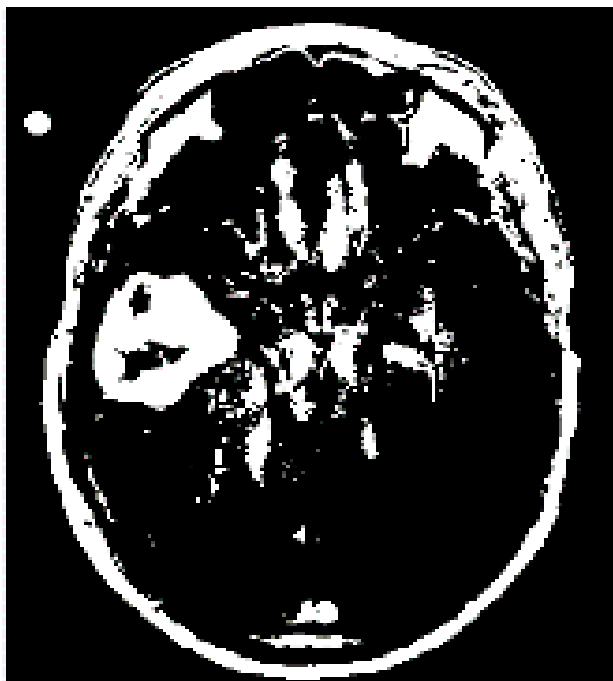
Binary image form of input MRI image.
